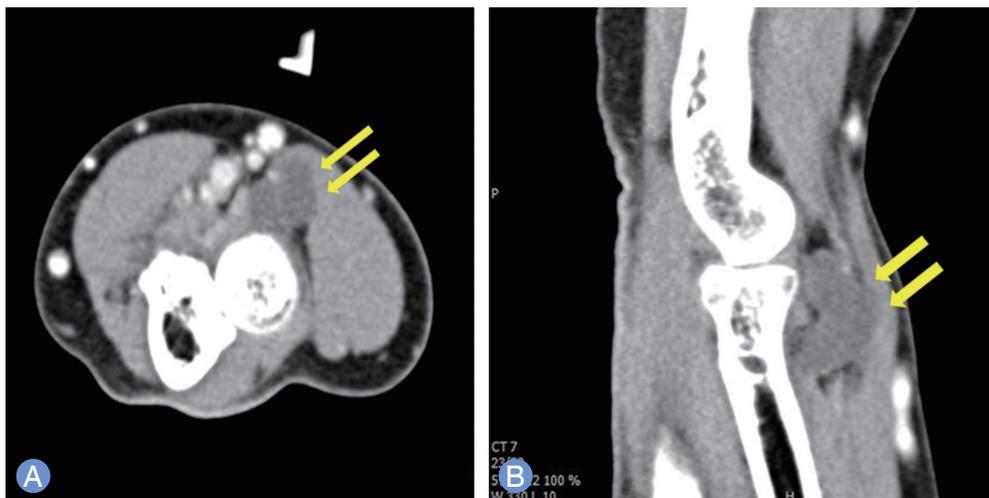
Preoperative computed tomography shows a lobulated cystic lesion (arrows) arising from a volar radial aspect of the proximal radius. (A) Axial view. (B) Sagittal view.
